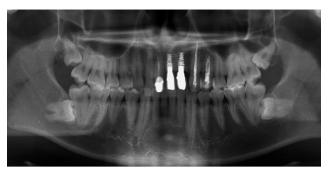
Two-year retention radiograph.
